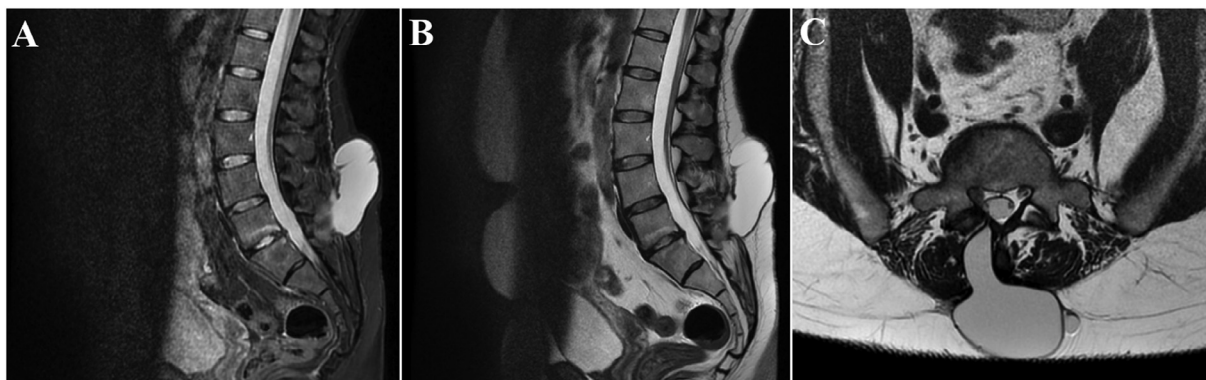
Lumbosacral spine MRI performed after one year after the previous surgery showing a voluminous subcutaneous CSF-like signal collection in sagittal FLAIR (A), sagittal (B) and axial T2-weighted images (C), communicating with the right L5-S1 interlaminar space, strongly suspected for pseudomeningocele.
